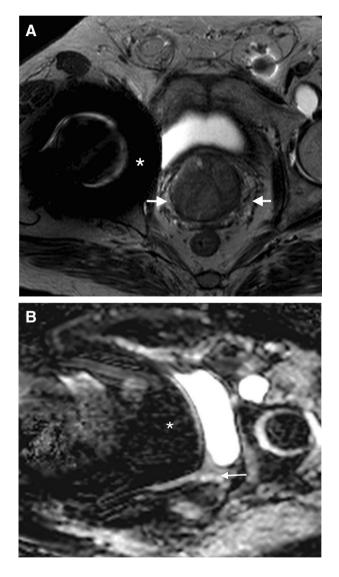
a and b Images from a patient with a hip implant acquired in T2-w (a) and DWI-ADC map (b) in a 3T system. The severity of susceptibility magnetic artifacts (asterisk in both images) is greater in the high-field equipment and is worse in DW images, where the prostate can barely be seen, compared to T2-w, where the prostate is well depicted (white arrows in both images). The Echo-Planar sequences, common in DWI, are prone to these artifacts
